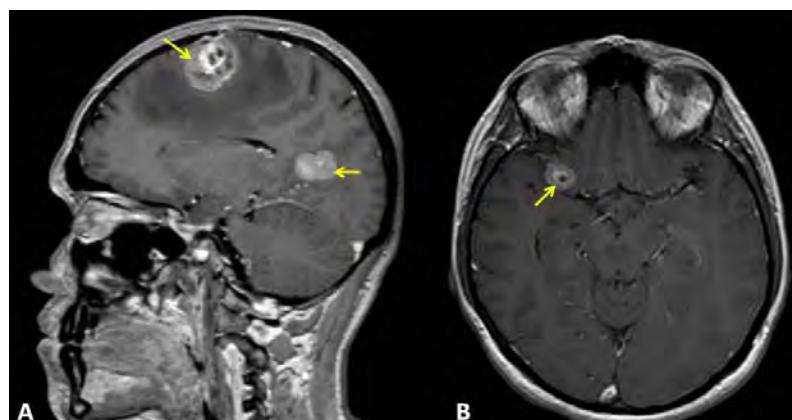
Contrast-enhanced MRI findings: T1 sagittal (A) and axial (B) reconstructions reveal multiple nodular cortico-subcortical lesions located in the supratentorial and infratentorial regions suggestive of cerebral metastases. The largest ones are located in the left frontal and parietal-occipital lobe and right frontal lobe (yellow arrows).
